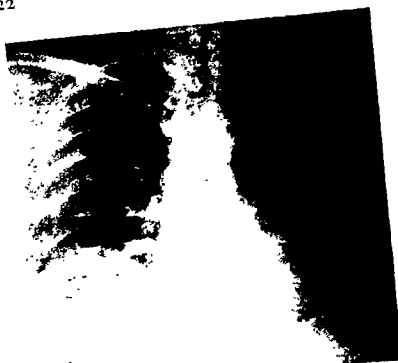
Case 197-38. Aged fifty-five. Began working at age of fourteen. Talc mill laborer and foreman forty-one years. Complains of fatigue. *Physical examination:* Chest expansion $1\frac{1}{2}$ inches; clubbing of fingers. *Roentgen examination:* Shows marked elevation of right diaphragm with obliteration of the costophrenic sulcus. On the left leaf of the diaphragm is a deposit of opaque material. Both lungs show a fine, granular fibrosis.
